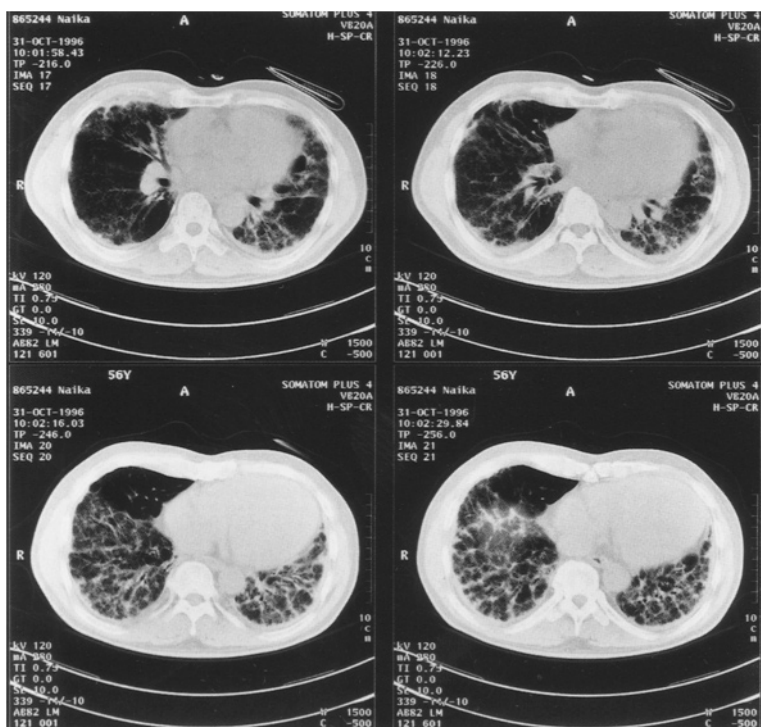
CT images show diffuse interstitial fibrosis in both middle and lower lung zones
